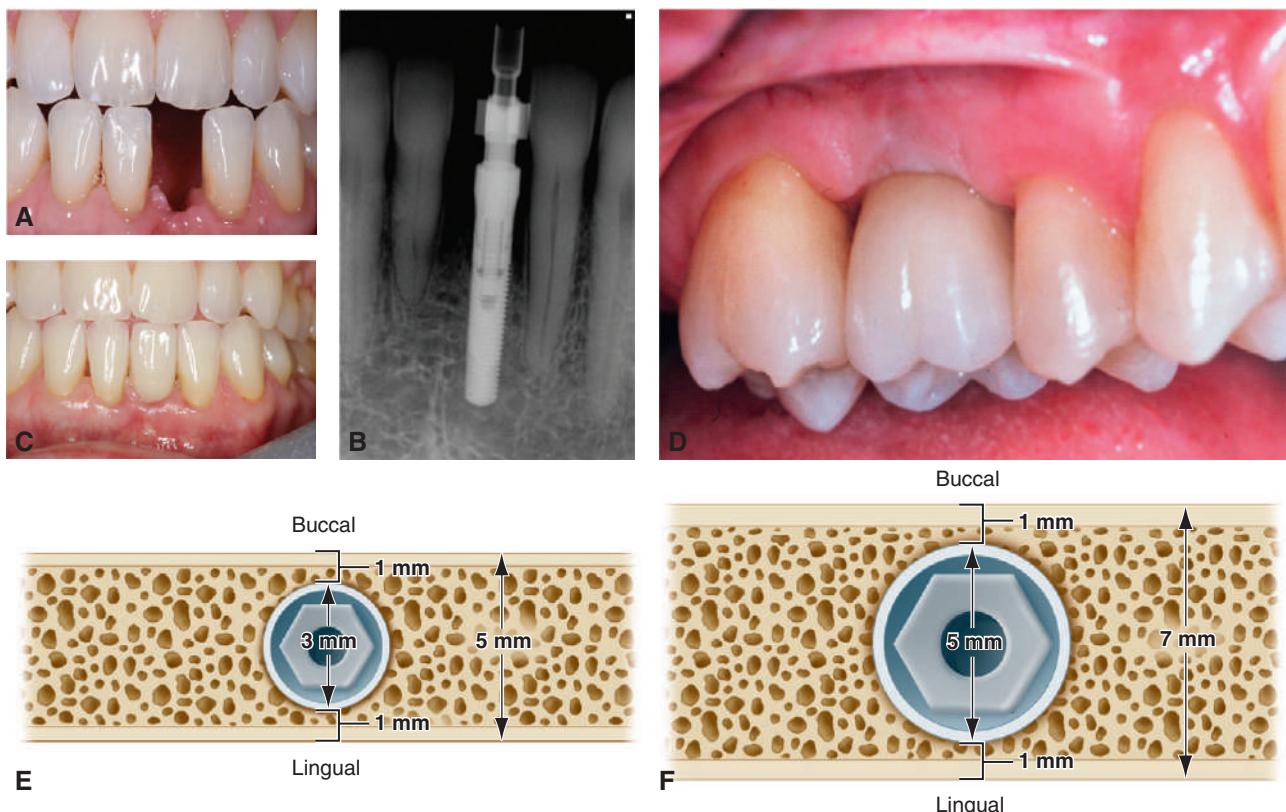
(A) Missing mandibular central incisor. (B) Radiograph of narrow diameter 2-piece implant. (C) Completed screw-retained crown for mandibular central incisor. (D) Completed implant restoration of the maxillary first molar. (E) The minimum bone dimension for a small diameter implant is 5 mm. Ideally, at least 1 mm of bone is still left on either side of the implant site after the osteotomy has been prepared. (F) The minimum bone dimension for a wider (5 mm) implant is approximately 7 mm. At least 1 mm of bone should still remain laterally after the site has been prepared.
